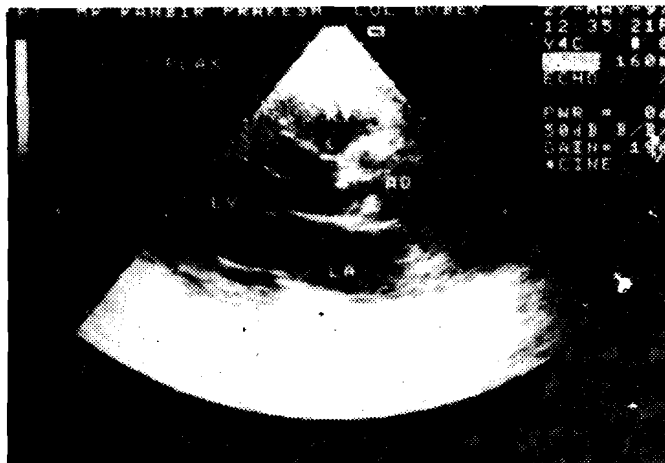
Echocardiogram of 62 year old male with RIID with severe calcific AS with moderate AR (courtesy Dr. S. Dwivedi and Dr. S.S. Giri)
